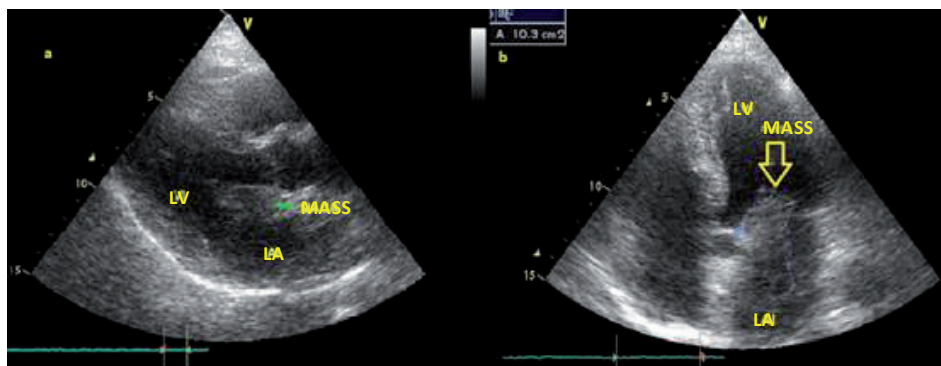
Transthoracic echocardiography. a. Long axis parasternal section. b. Long-axis four-chamber view. The image suggests a large mass that involves the atrial septum, anterior mitral valve, and anterior aortic leaflet. LA: Left atrium. LV: Left ventricle.
